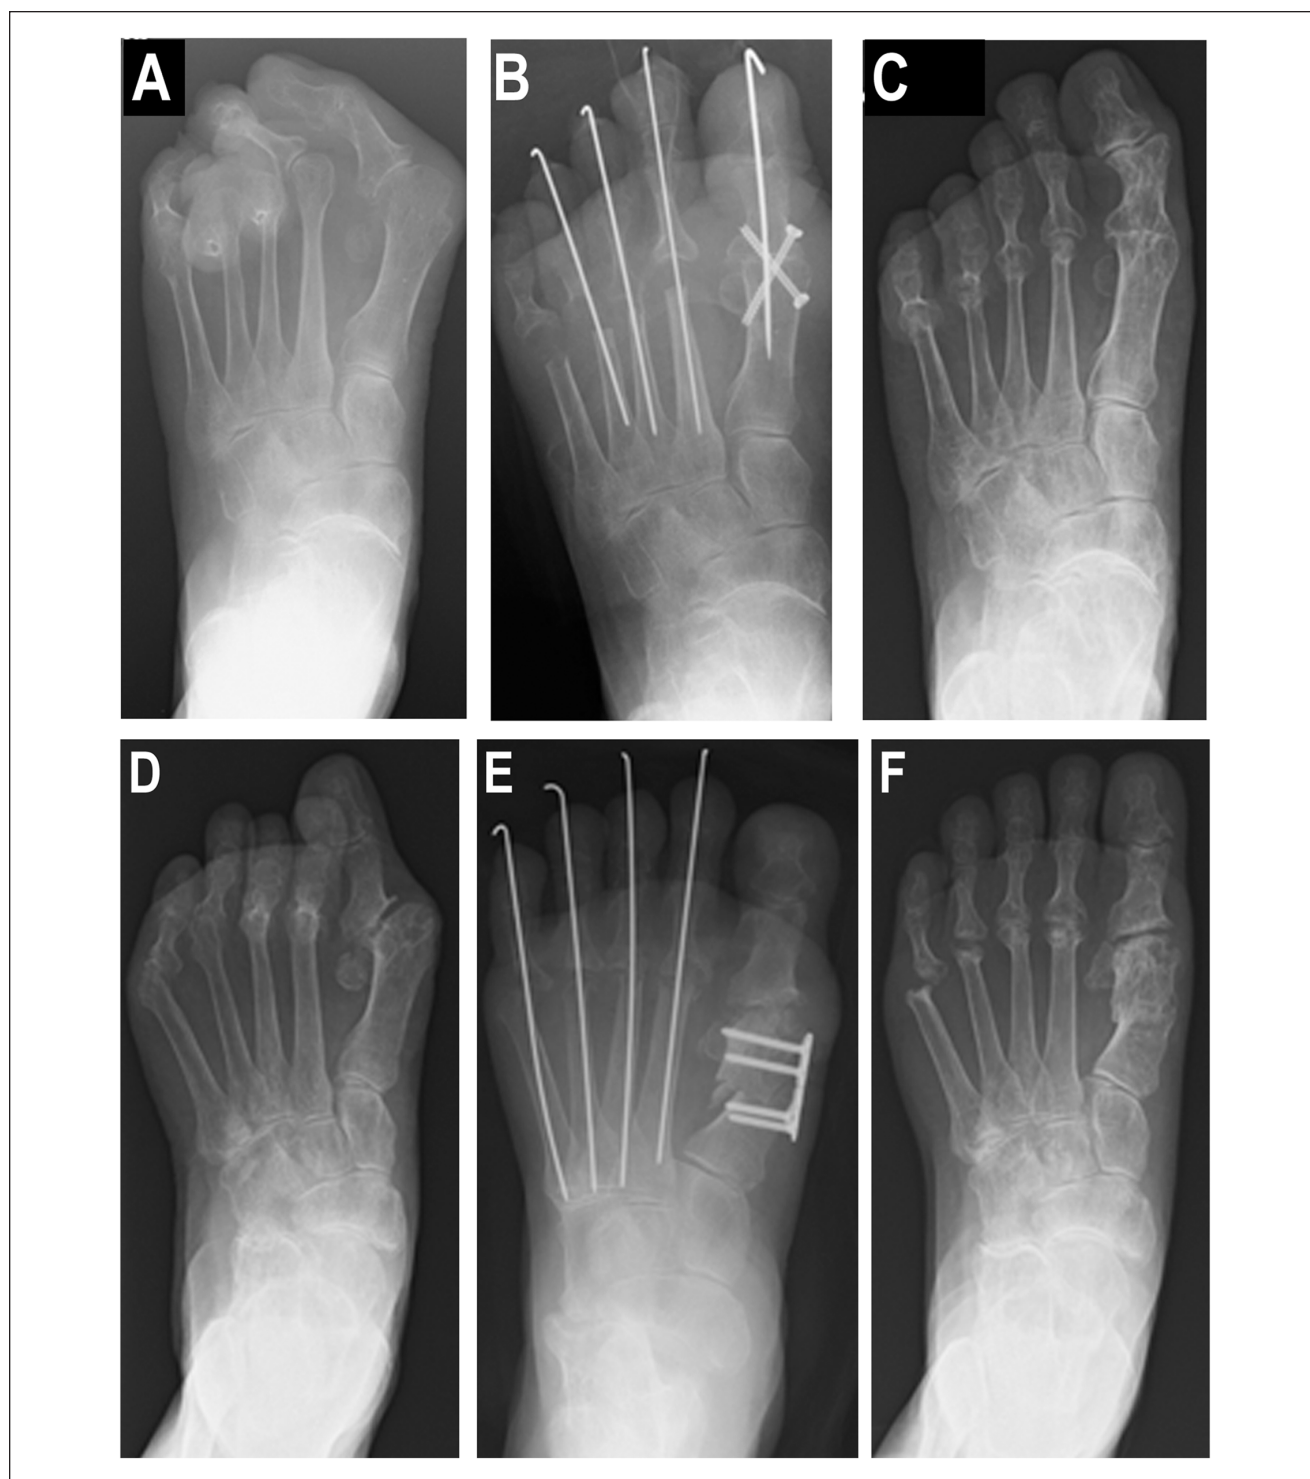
Top: Representative preoperative and postoperative radiographs of a 54-year-old woman who underwent arthrodesis of the first metatarsophalangeal (MTP) joint and resection arthroplasty of the lesser toes. (A) The preoperative hallux valgus angle (HVA) was 73 degrees, and the preoperative total Japanese Society for Surgery of the Foot (JSSF) scale score was 52. (B) Radiographs immediately after surgery with arthrodesis of the first MTP joint and resection arthroplasty of the lesser toes. (C) The final HVA was 13 degrees and the final total JSSF scale score was 70. Bottom: Representative preoperative and postoperative radiographs of a 73-year-old woman who underwent first MTP joint preservation and resection arthroplasty of the lesser toes (bottom). (D) The preoperative HVA was 38 degrees and the preoperative total JSSF scale score was 34. (E) Radiographs immediately after surgery with the first MTP joint preservation and resection arthroplasty of the lesser toes. (F) The final HVA was 16 degrees, and the final total JSSF scale score was 75.
